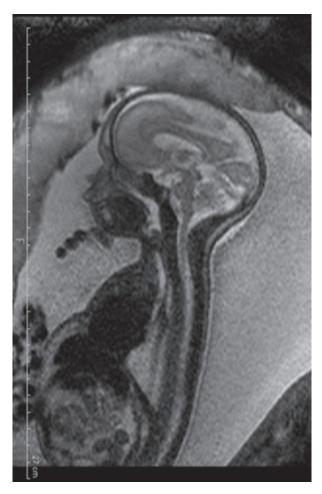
MRI of the CHAOS, with a sign of obstruction being the disappearance of the liquid signal from the trachea.
